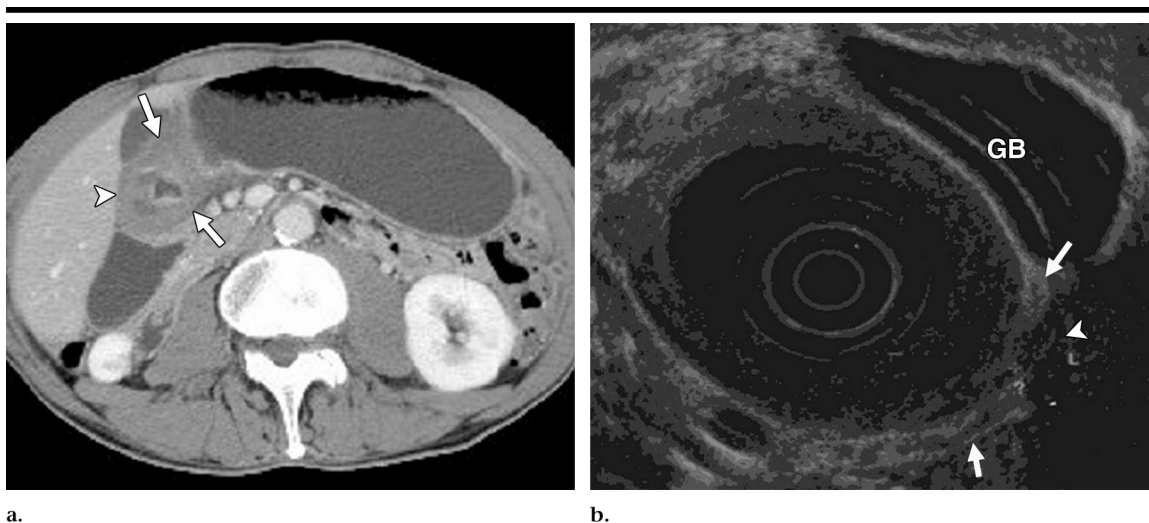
Images of a 52-year-old woman. (a) Transverse CT image of a transmurular tumor of the antrum (arrows) with blurring and obliteration of the fat plane between the gastric wall and the liver and additional invasion of the liver (arrowhead). This tumor was correctly staged as T4. (b) Endoscopic US image that corresponds to a shows a tumor (arrows) involving the gastric wall and the adjacent liver (arrowhead). (GB = gallbladder).
